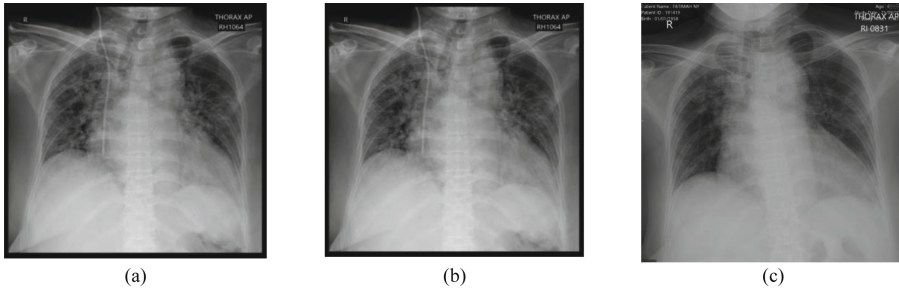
Case 3. (a) first thorax radiograph. (b) after the secretome last injection. (c). 3 weeks after last secretome injection.
